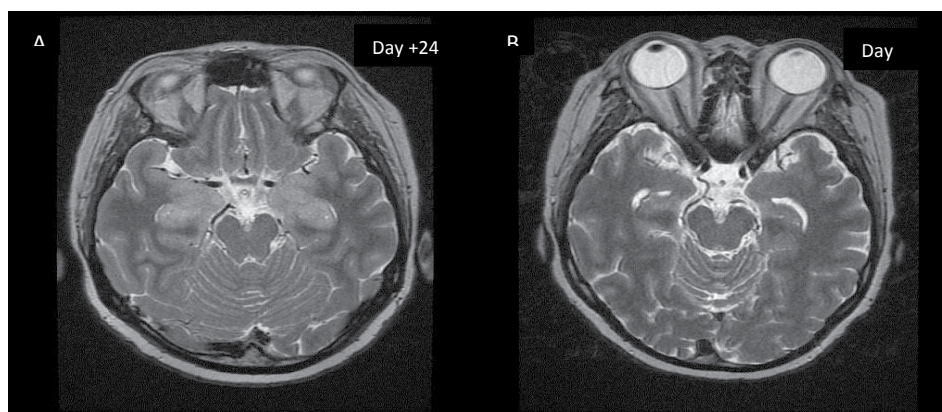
Cranial MRI showing increased T2-weighted signals in bilateral amygdala, hippocampus and left basal ganglia (A) and resolution after anticoagulation (B).
